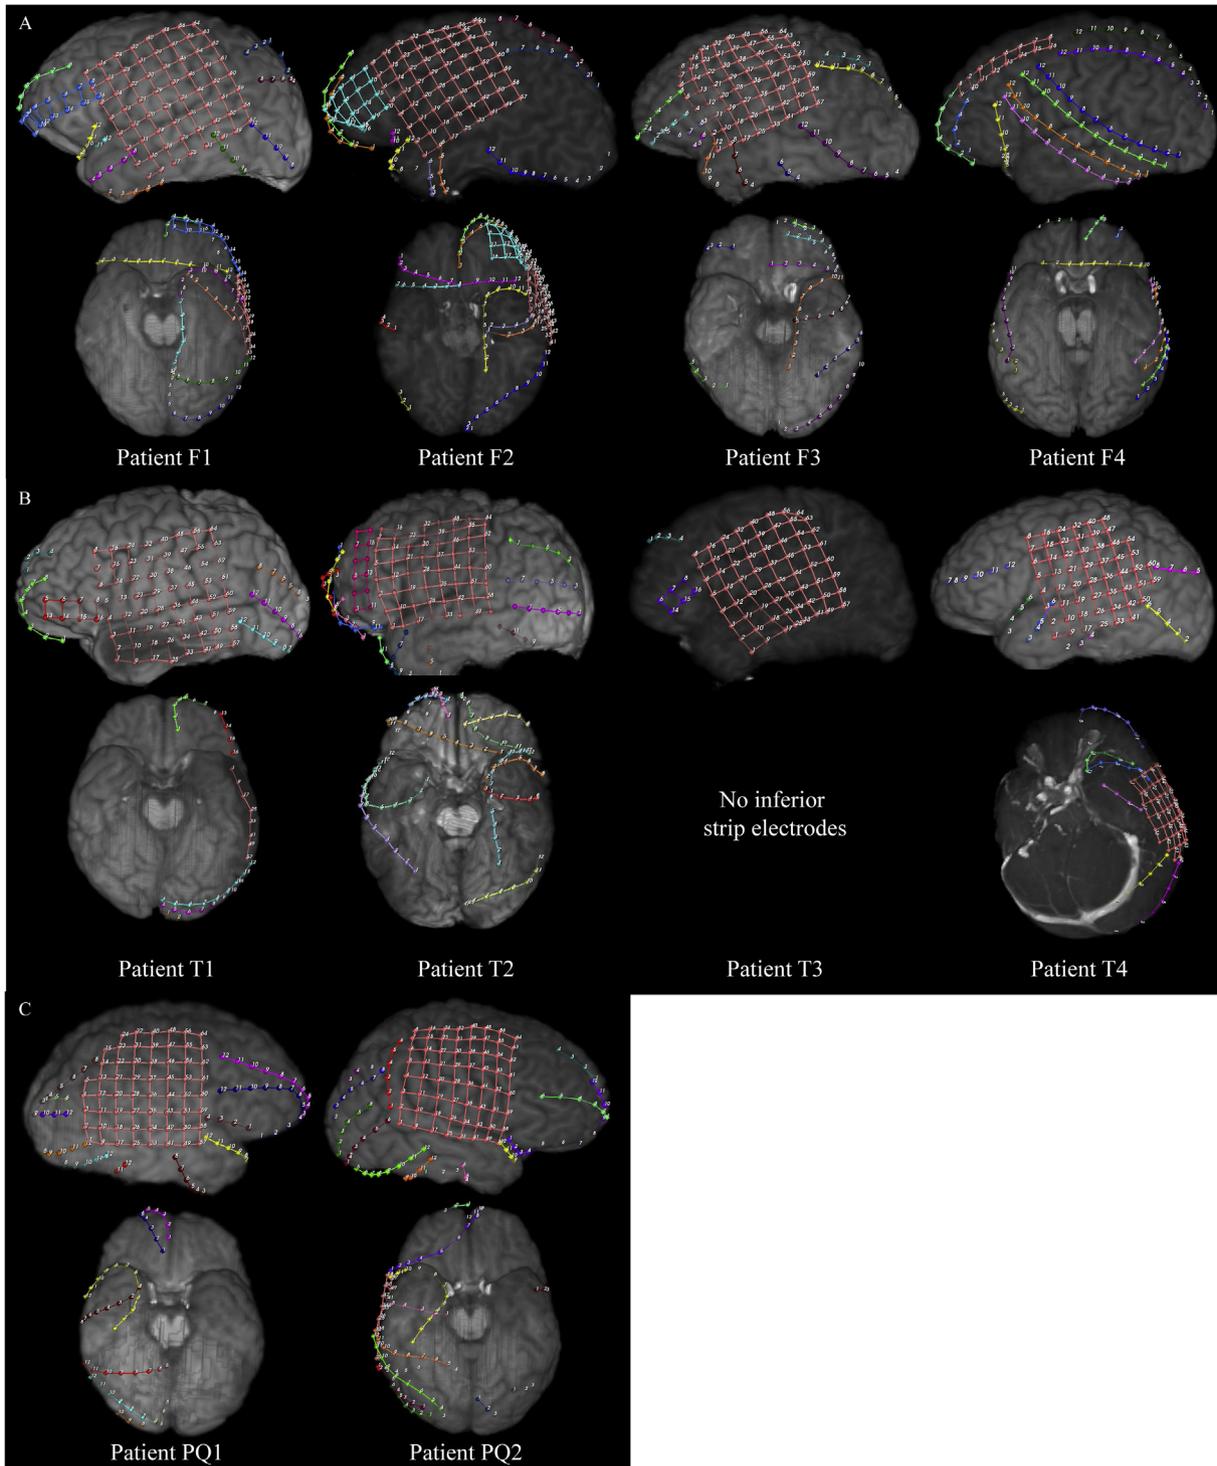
Patient specific cortical surface reconstructions with implanted electrodes localized in radiographic space. (A) frontal cohort, (B) temporal cohort, (C) posterior quadrant cohort. Note that only surface electrode contacts, not depth electrode contacts, are pictured.
